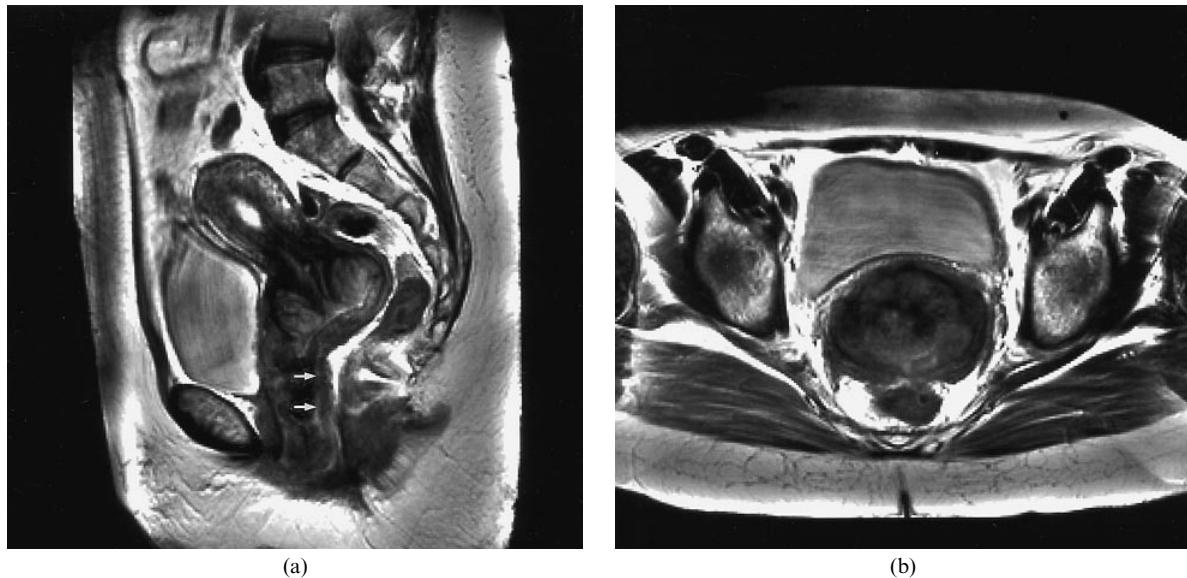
MRI scan of the pelvis using T_2 weighted FSE sequences: (a) sagittal plane and (b) axial plane. The mass of relatively high signal intensity is seen within the thickened vaginal wall and uterine cervix. Note the high signal intensity line indicating an intact posterior vaginal endothelium (arrow).
